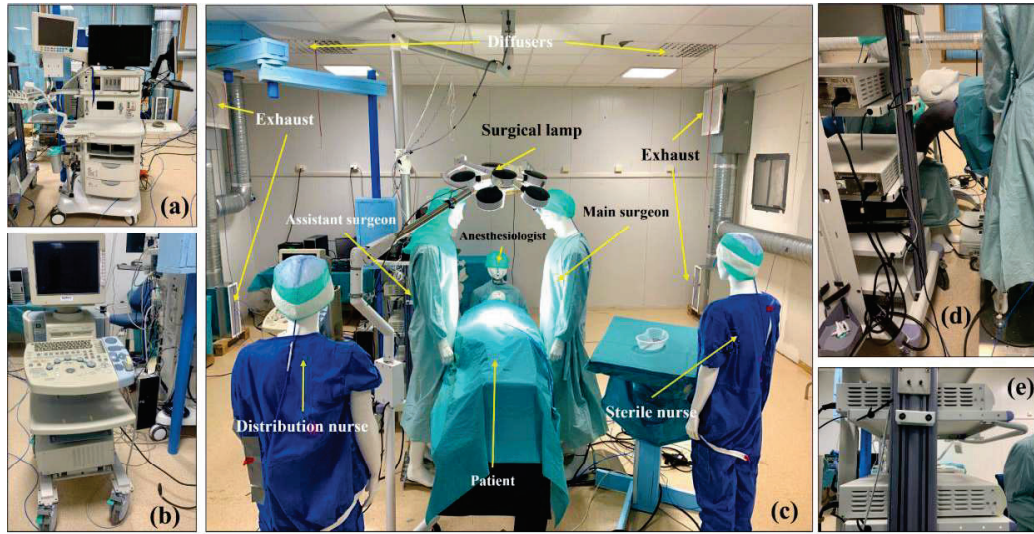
Medical equipment and layout in the OR. (a) Anesthesia machine; (b) Ultrasonic imager; (c) the layout of the OR laboratory; (d) Endoscope imager; (e) The cooling fan of the endoscope imager
